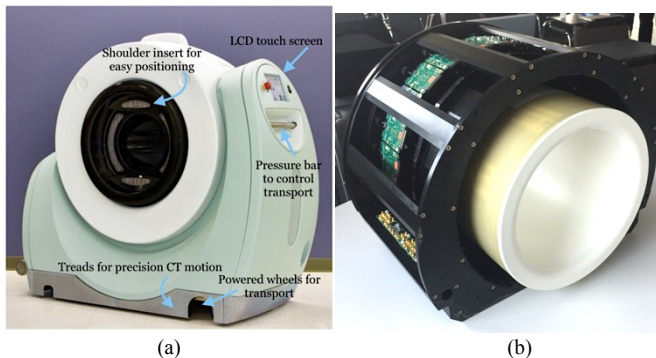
(a) PhotoDiagnostic system PET-CT at MGH, this figure was originally published in [42]. (b) SPECT, MR-compatible, system called INSERT, image courtesy of B. Hutton (UCL).
